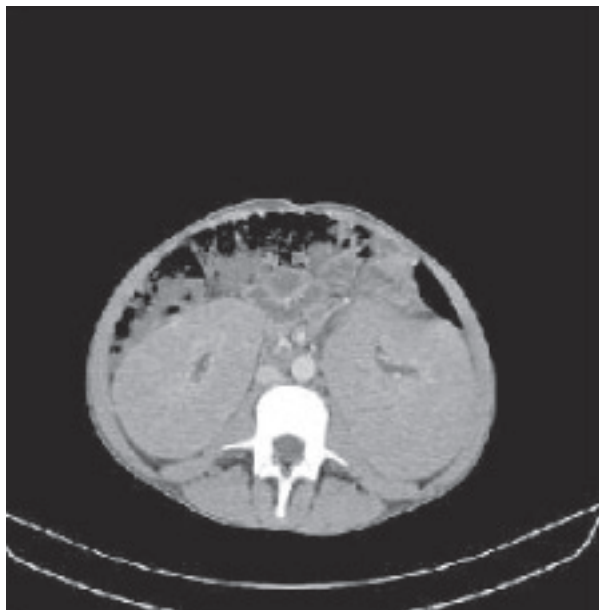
Computed tomographical examination revealed bilateral diffuse renal enlargement without any functional abnormality. There was no detectable focal lesion in the both kidney.
